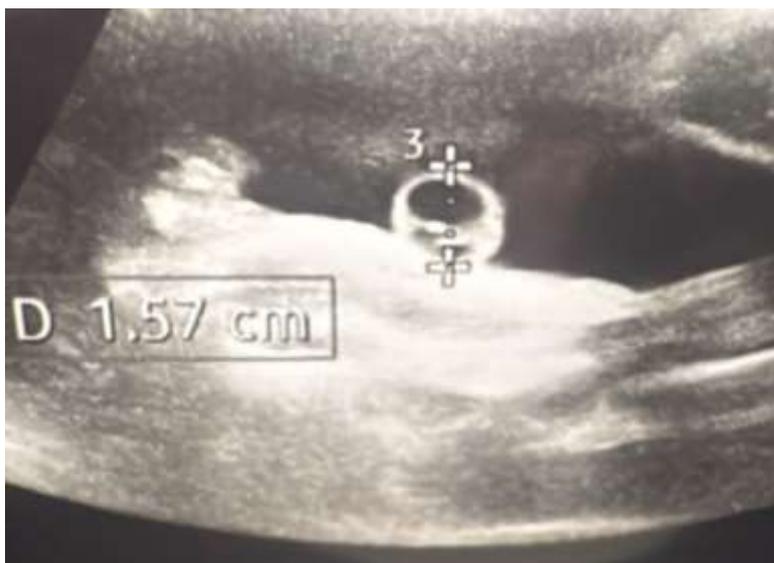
Demonstrates measurement of the umbilical cord diameter 1.57 cm using Mindary ultrasound machine for the fetus of 28 years old pregnant woman.
